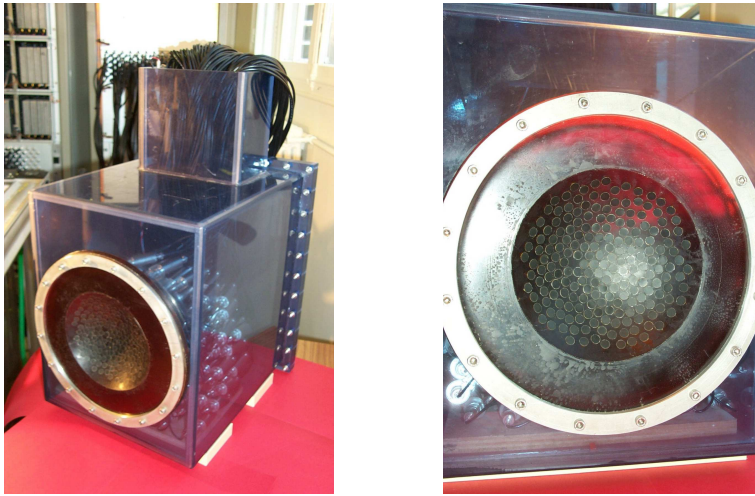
Therapeutic ultrasound array used by Pernot et al. (2007). Photos: Pernot (2004)
